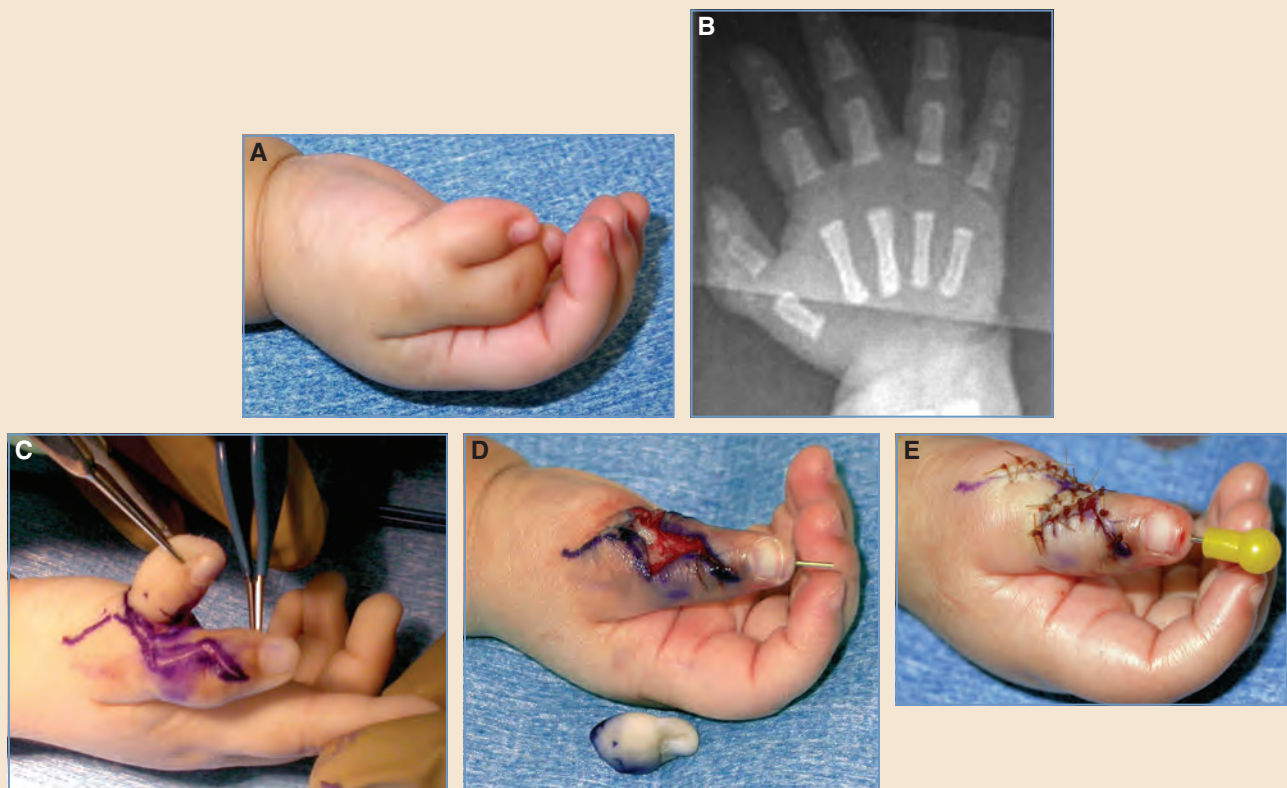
Wassel type IV polydactyly. A, Asymmetrical duplication at the metacarpophalangeal joint. B, The radiographic appearance. C, A zigzag incision with a racquet-shaped excision. D, Care in tendinous and ligamentous alignment. E, Flap closure and K-wire fixation.
